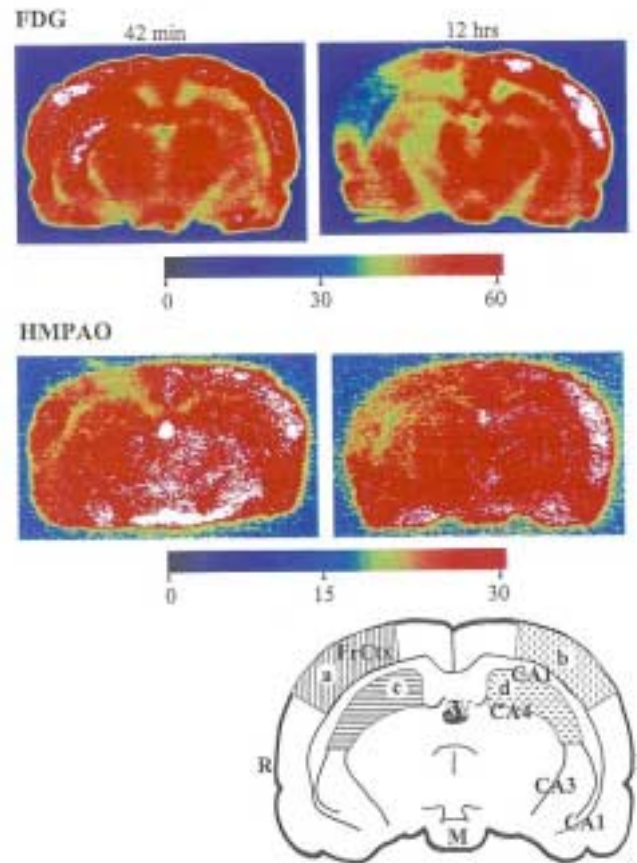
Autoradiographic images of FDG and HMPAO at 42 min (left) and 12 h (right after fluid percussion injury). The images were taken at 5 mm posterior to bregma. CA1-4; fields 1-4 of Ammon's horn. R- right, L- left, 3V, third ventricle, M, corpora mammillaria. FrCTX, frontoparietal cortex; trauma site (a) and (b) for the opposite cortical ROI. (c) and (d) denotes the ipsi- and contralateral hippocampal ROIs, respectively.
